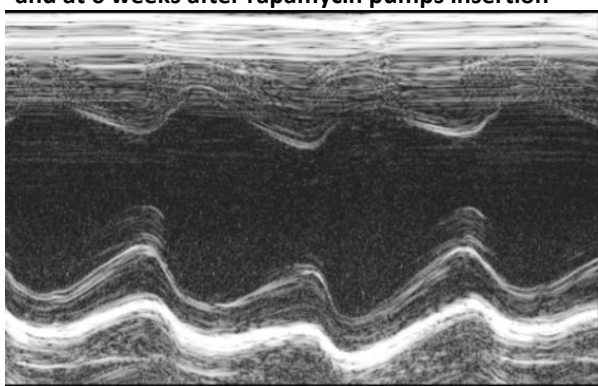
Representative M-mode echocardiographic images in MR hearts before and at 6 weeks after rapamycin pumps insertion
